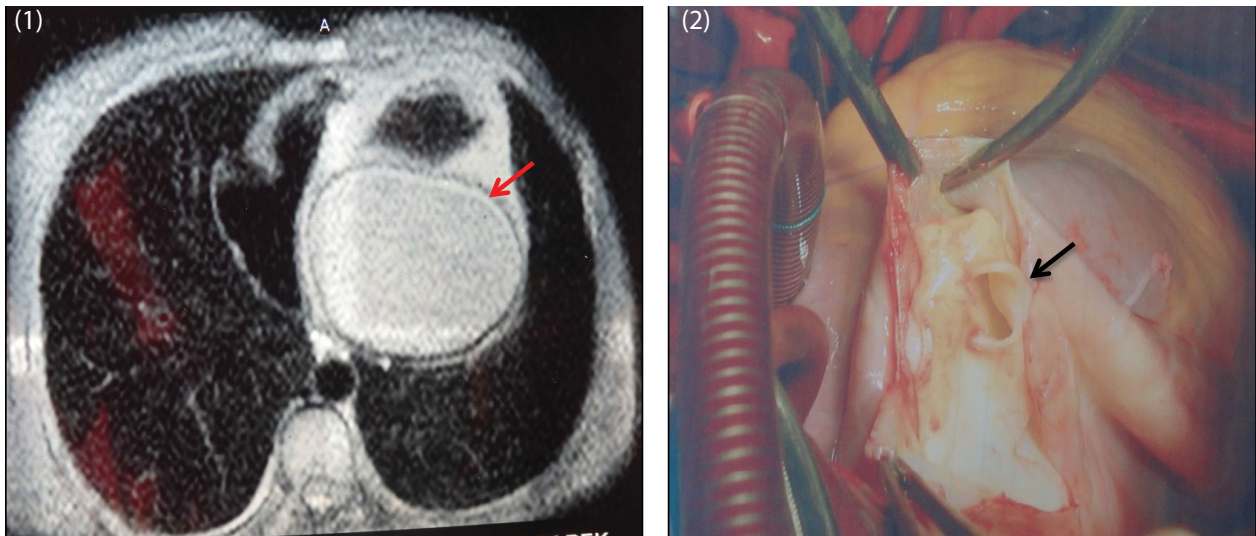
Thoracic magnetic resonance imaging revealing a giant left ventricular hydatid cyst (arrow).
